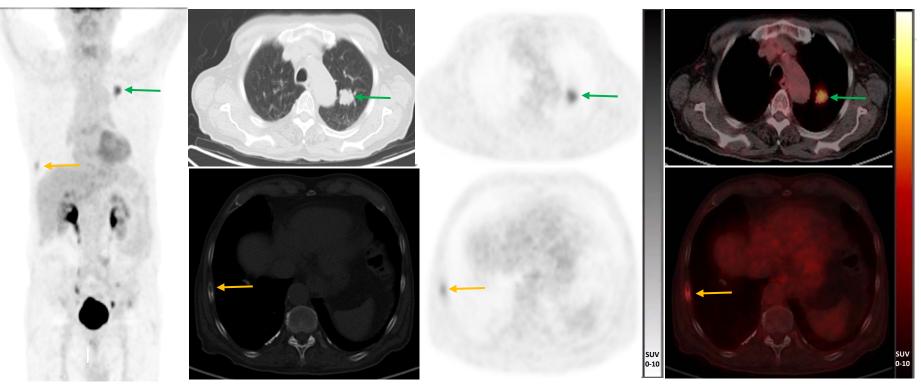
[18F]FDG PET/CT Scan
